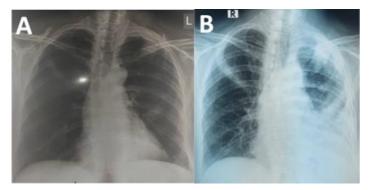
Chest X-ray after administration of EGFR-TKI for 13 months (A) and 17 months (B).
